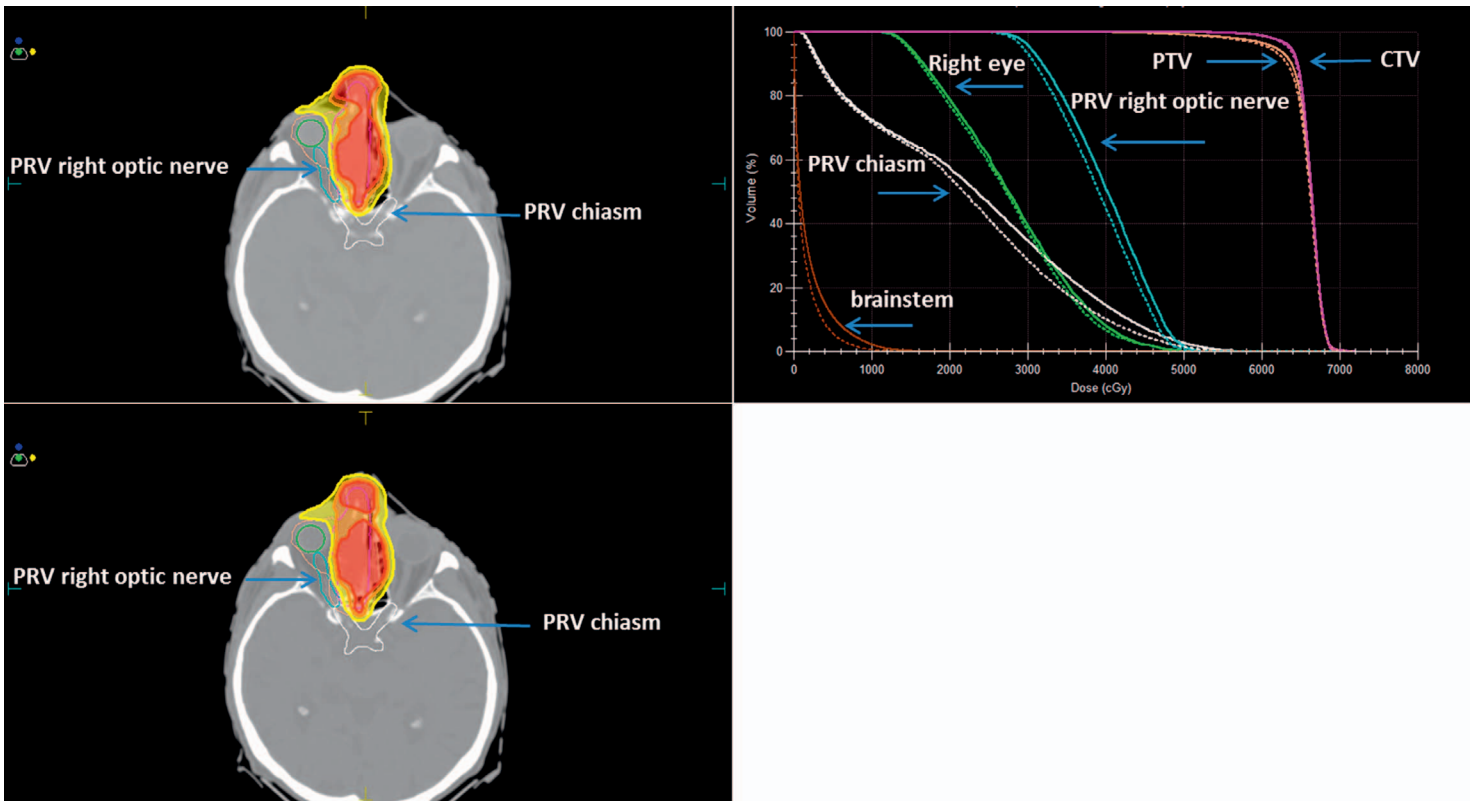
Comparison of a planning dose-volume histogram and a dose-volume histogram obtained from a weekly computed tomography scan showing consistency in target coverage and sparing of the organs at risk.
